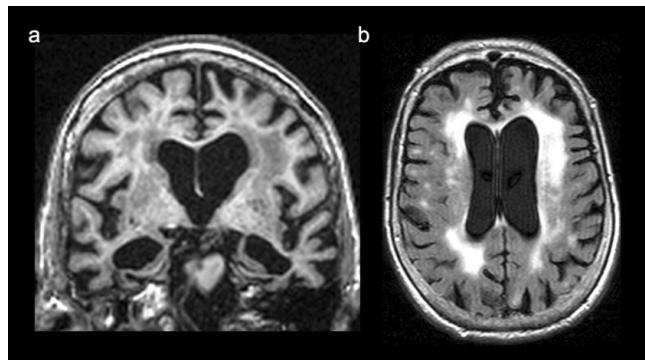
Representative case of a 91-year-old male patient with Alzheimer's disease. (a) Coronal reformat of a 3D T1-weighted sequence shows severe widening of the choroid fissures and severe enlargement of the temporal horns, with marked atrophy of both hippocampi (Medial temporal lobe atrophy – MTA – score of 4). (b) Axial T2-FLAIR sequence reveals hyperintensities involving the periventricular and the deep white matter, with irregular periventricular signal extending to the deep white matter in the former and severe confluence in the latter (periventricular and deep Fazekas score of 3).
